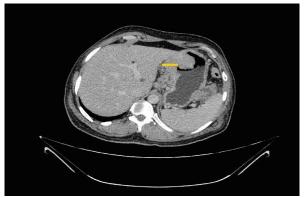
CT abdomen showing thickened wall of lesser curvature
